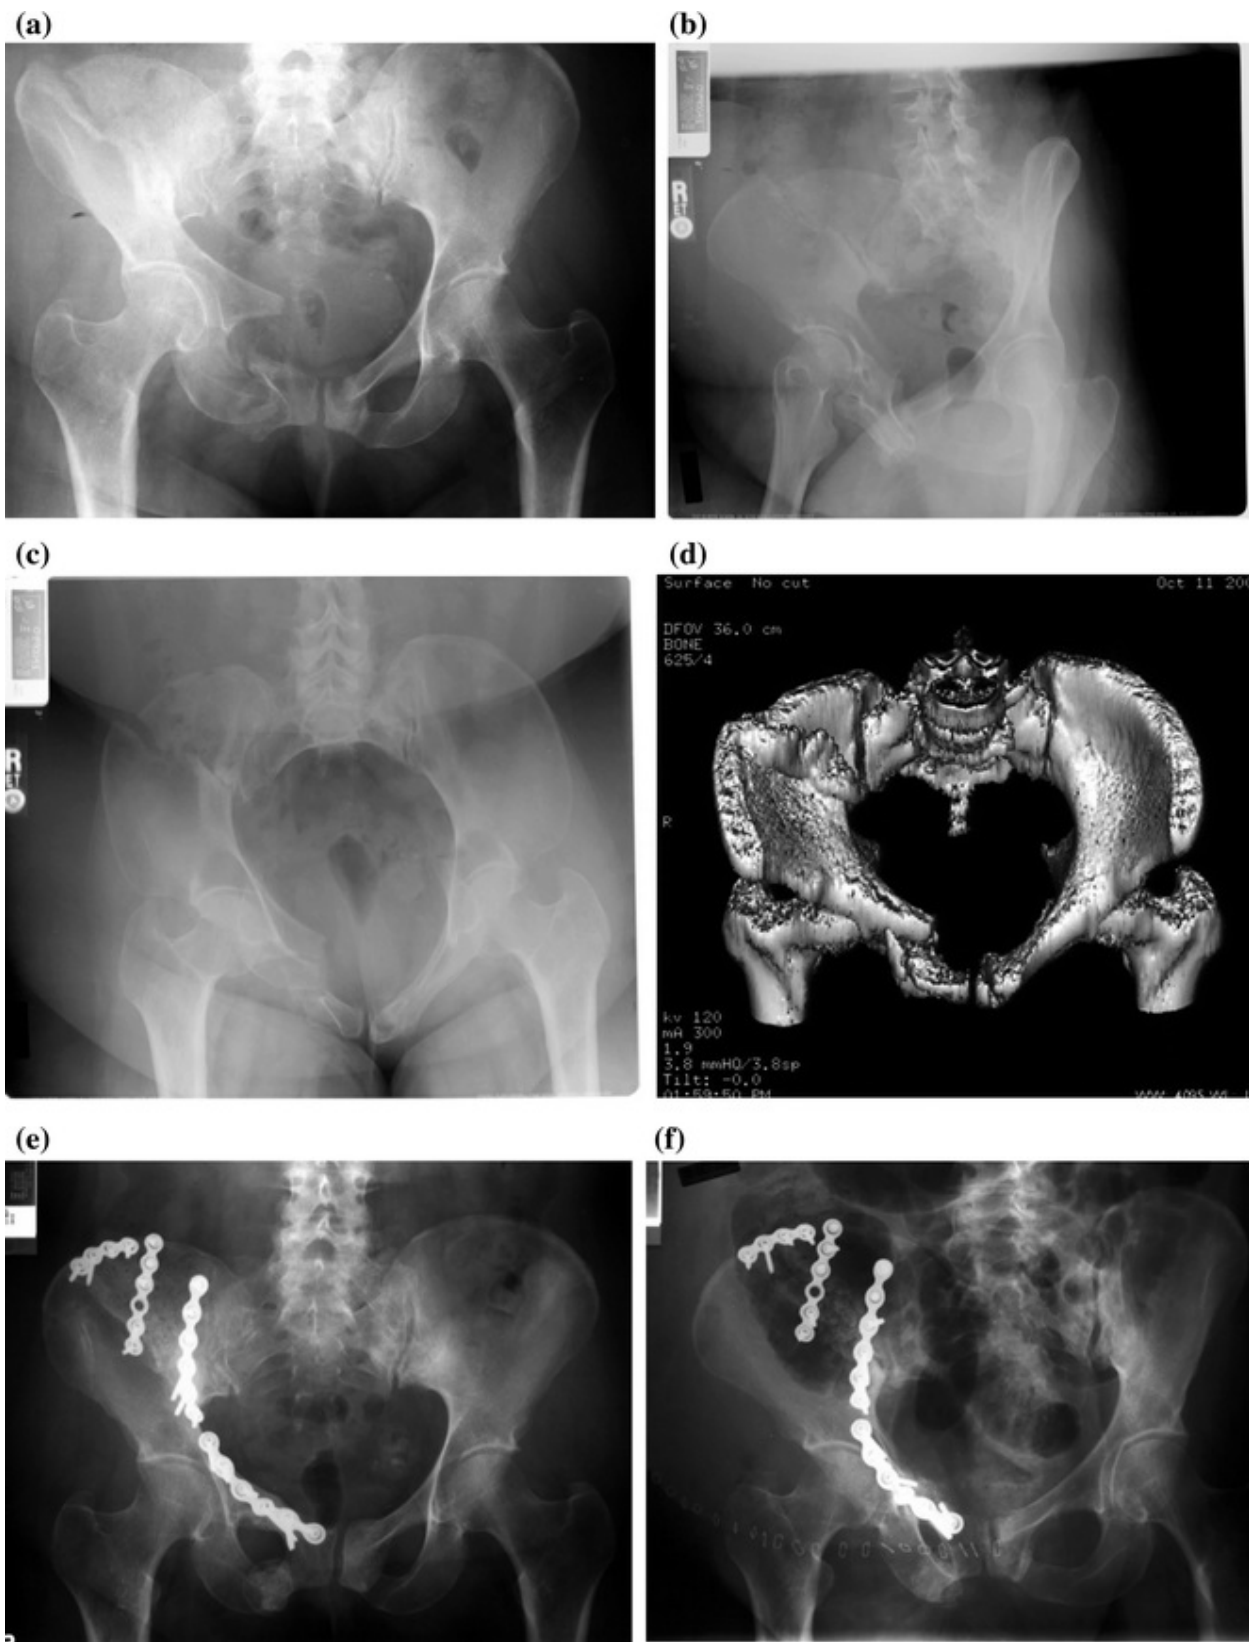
a–c Anteroposterior (AP), iliac oblique, and inlet X-rays of pelvis demonstrating the pelvic
